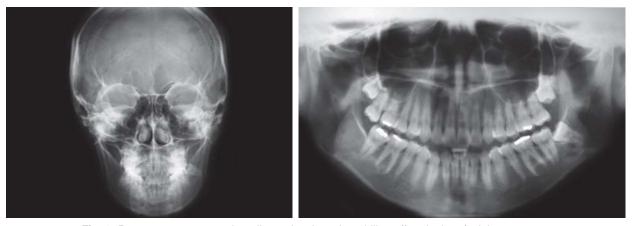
Pretreatment panoramic radiographs show the midline off and minor facial asymmetry
